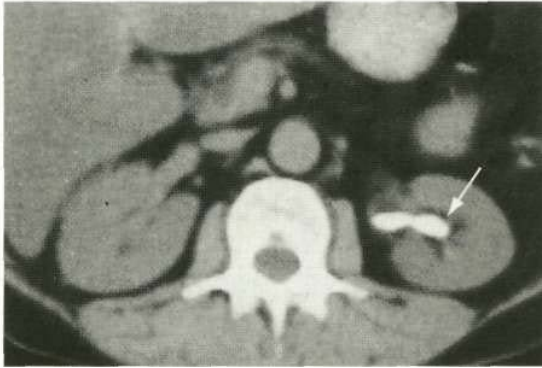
CT scan, showing a uric acid stone, which appears as a bright lesion in the left kidney (arrow).
